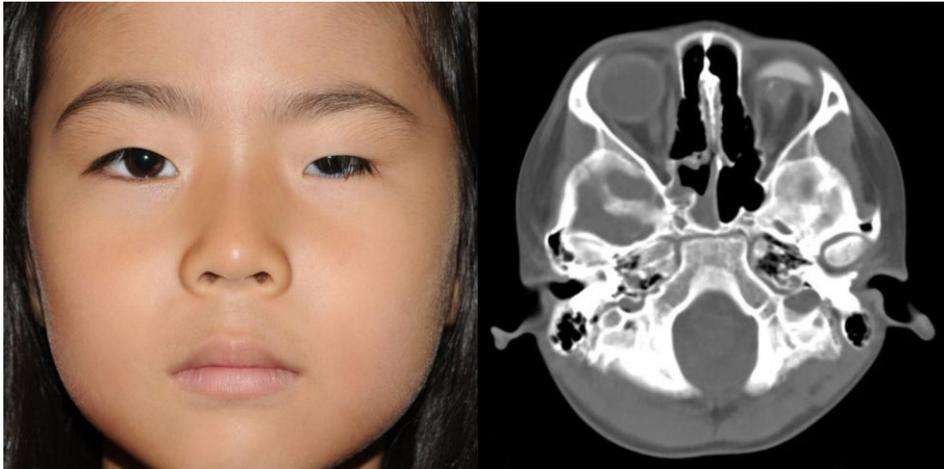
A Photograph and a computed tomography scan of a patient with orbital hypoplasia and facial asymmetry who started an initial wearing of the prosthesis at 72 months of age (Case 26)
